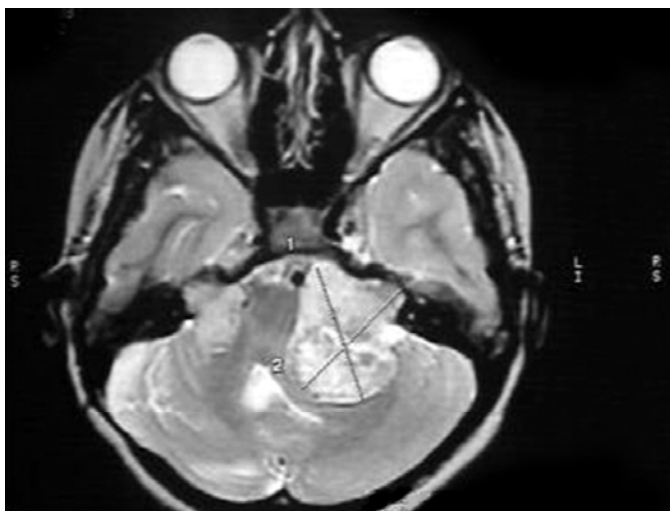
MRI of neurofibromatosis type 2
